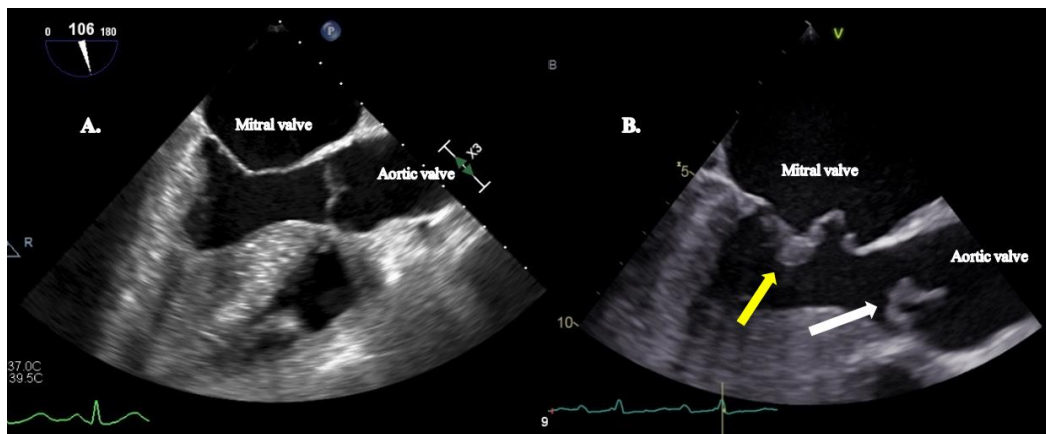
Normal mitral and aortic valve morphology compared with mitral valve vegetation and aortic valve vegetation and destruction. A. shows normal mitral and aortic valves. B. shows vegetation on the mitral valve (yellow arrow) and vegetation and valvular destruction on the aortic valve (white arrow) caused by coagulase-negative staphylococci detected by transoesophageal echocardiography.
